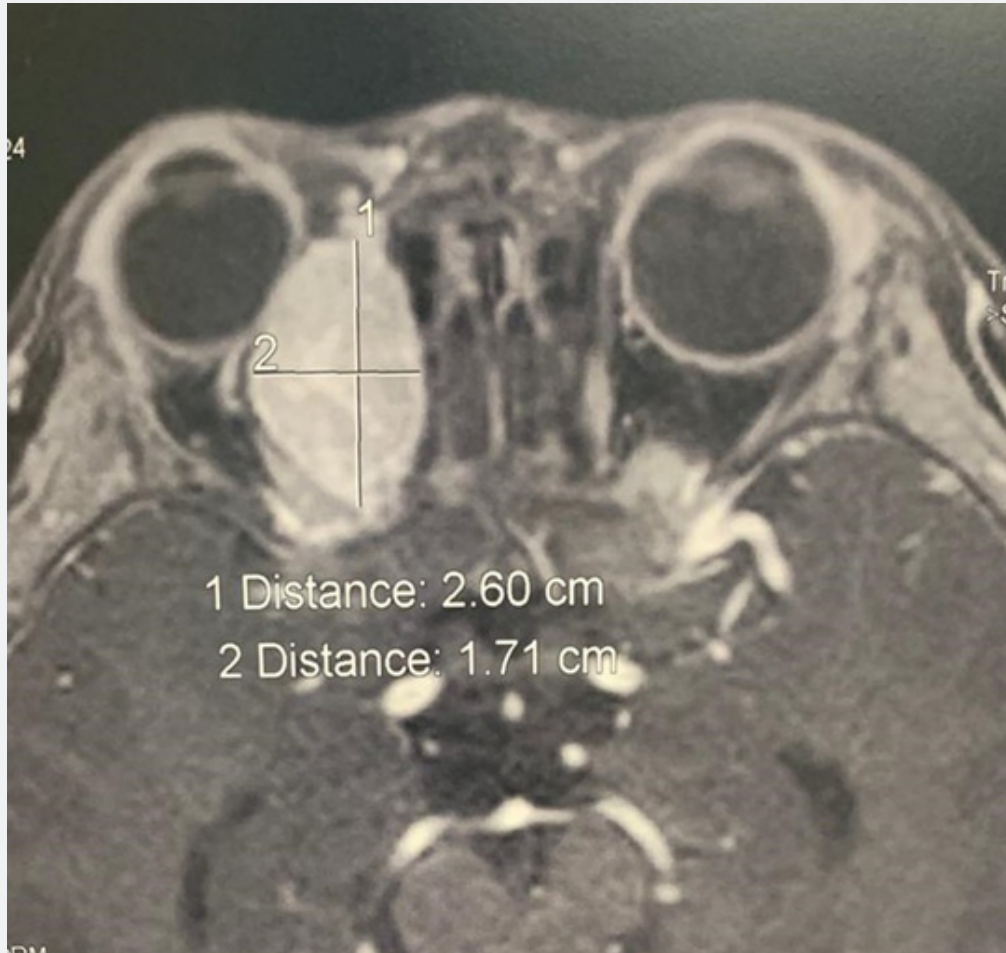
MRI T1 with contrast showing right orbital mass compressing onto the optic nerve.
